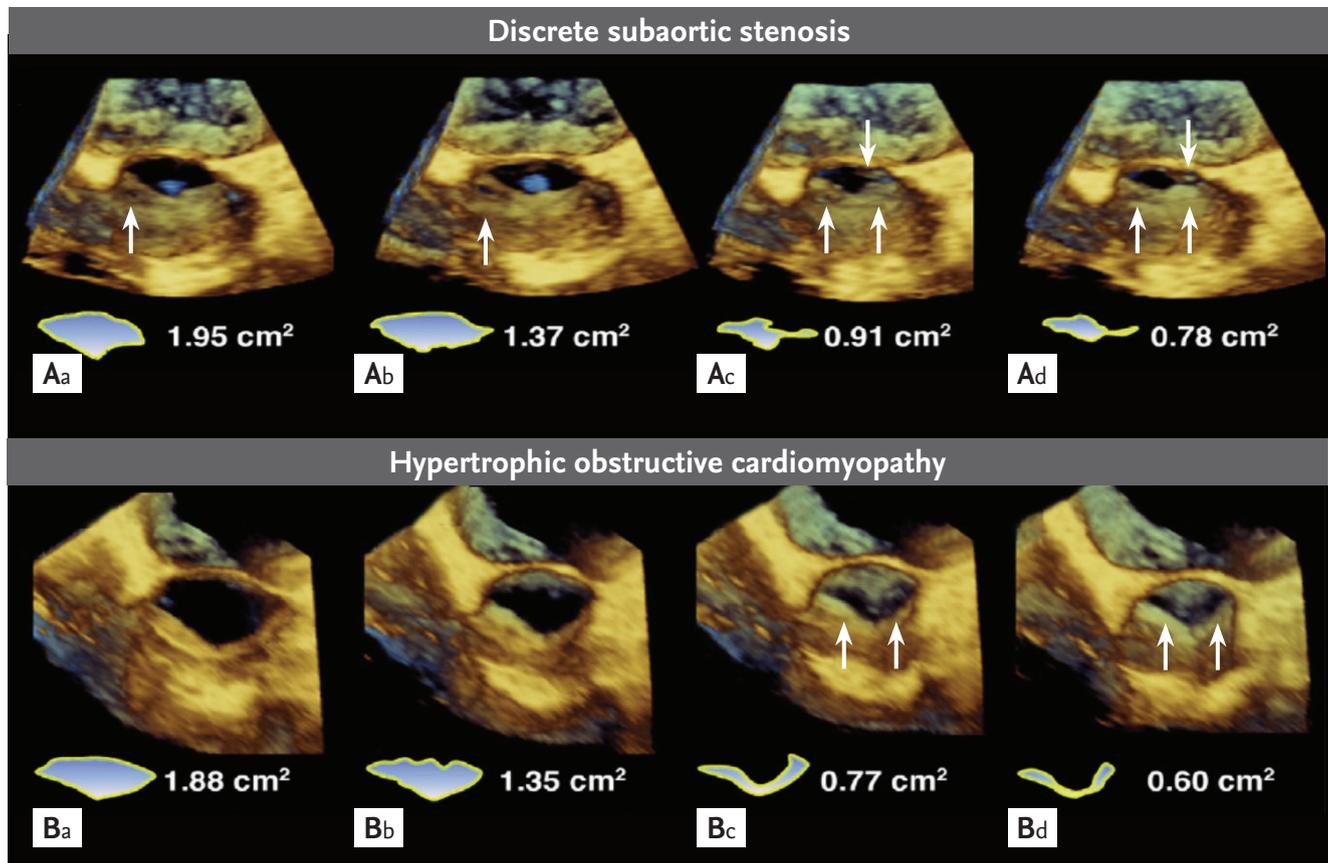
Real-time three-dimensional transesophageal images, showing the difference in the shape of left ventricular outflow tract (LVOT) between discrete subaortic stenosis (DSS) and hypertrophic obstructive cardiomyopathy. (A) The DSS images show the almost oval or flat shape of the LVOT (Ad) and subaortic membrane with small fenestration at left upper site of membrane (Aa and Ab, arrow). The thin membranous structure changes its angle to decrease the LVOT area along the blood stream (Ac and Ad, arrows). (B) In hypertrophic obstructive cardiomyopathy, the shape of the LVOT is a V formation or two separate open spaces due to systolic anterior motion of mitral anterior leaflet (Bc and Bd, arrows).
